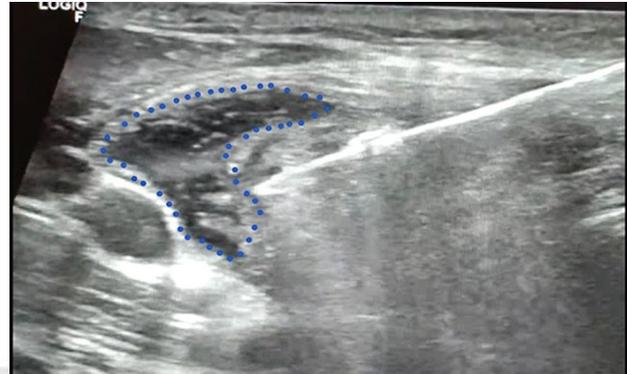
Ultrasound image showing hydrodissection. Adequate hydrodissection between the nodule and major neck vessels prevents damage to surrounding structures.
